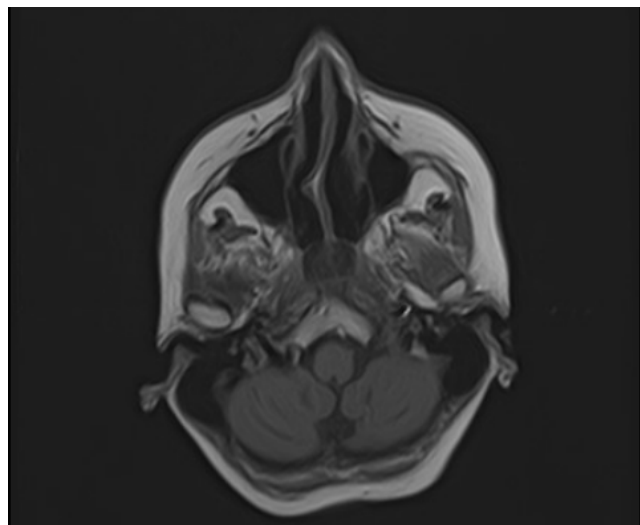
Brain MRI (T1 weighted image) revealed pathological increase in signal intensity in the area of the soft membranes of the cerebellum
